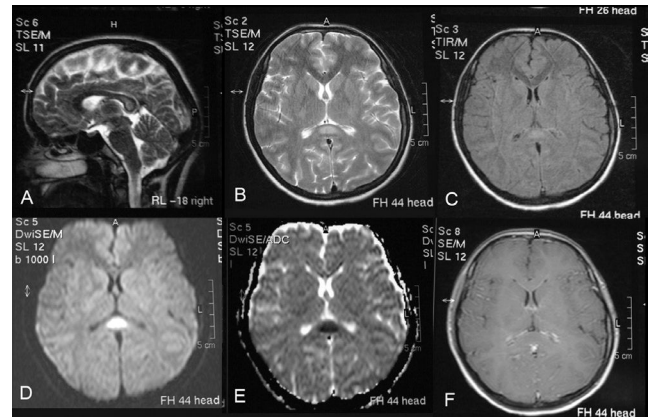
Sagittal T2-weighted image (a), transverse T2-weighted image (b), transverse FLAIR image (c), and diffusion-weighted image (d) showing a high-intensity signal in the splenium of the corpus callosum. Transverse apparent diffusion coefficient image (e) showing a low-intensity signal in the splenium of the corpus callosum. Contrast transverse T1-weighted image showing only some slight contrast enhancement of the leptomeninges (f)
